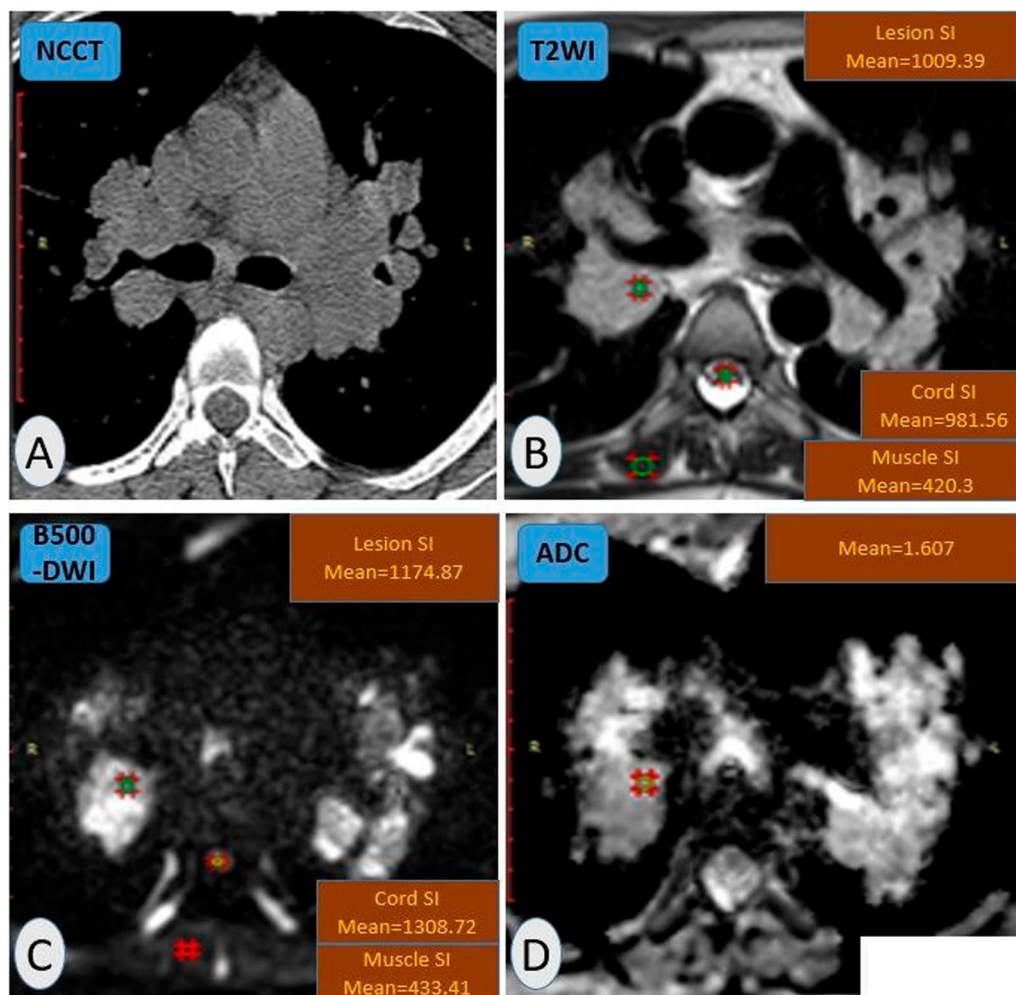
A 40 years-old-female patient complaining of dyspnea and cough. A Non-contrast enhanced chest CT with multiple mediastinal and bilateral hilar lymph nodes. B T2WI-MRI showed hyper-intense globular lymph nodes (compared to muscle signal) with lesion-to-cord signal ratio = 1 and lesion-to-muscle signal ratio = 2.4 (N.B: The relatively higher T2-signal is strikingly noticed compared to Fig. 4). C b500-DWI showed a bright signal of few nodal tissues still with lesion-to-cord signal ratio = 0.8 and relative contrast ratio = 1.7. D Also, the mean ADC value = $1. \times 10^{-3}$ mm²/s (no restriction) ... Pathologic proven sarcoidosis
